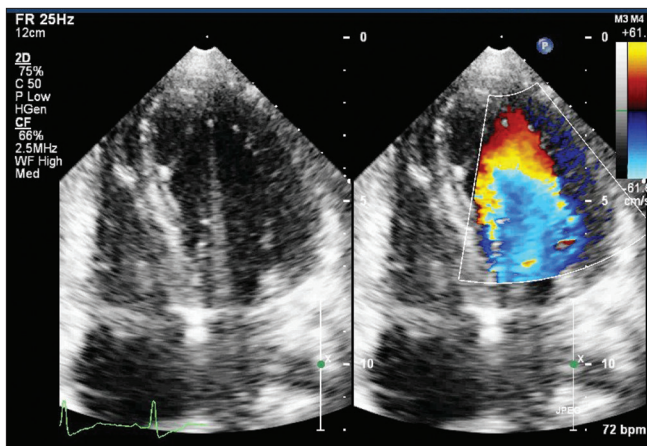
Transthoracic echocardiogram: long-axis modified four-chamber view showing the presence of trabeculations and deep intratrabecular recesses, with perfusion at end-diastole on Doppler echocardiography
